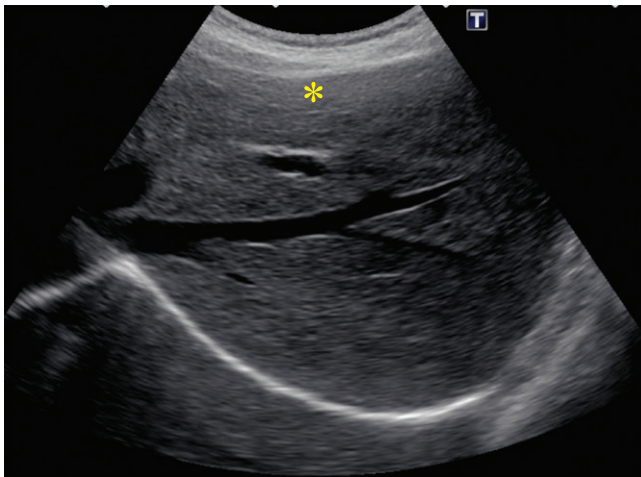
Fundamental gray scale ultrasound shows no abnormalities. There is distortion of the near field by artifacts from the body wall reverberations (*).
